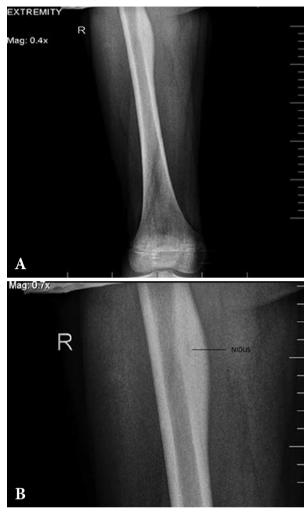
A) X-ray of the right femur with a homogeneous shadow in the proximal and medial part of the femoral shaft (standard image); B) Enlarged view shows a nidus in the upper third of the shadow (arrow)
